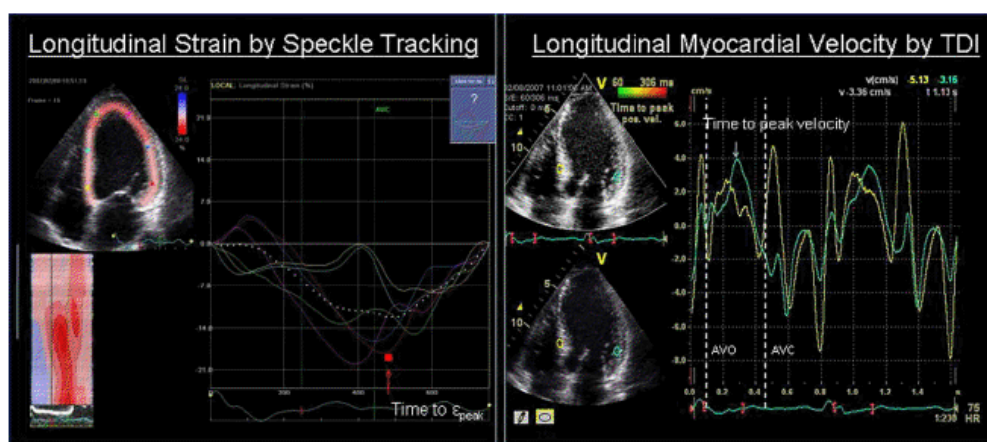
Peak longitudinal strain by speckle tracking was defined as the lower strain value during the cardiac cycle, and peak systolic velocity by TDI was defined as the maximum velocity value during the systolic period defined by aortic valve opening and closure. TDI, Tissue Doppler imaging.
